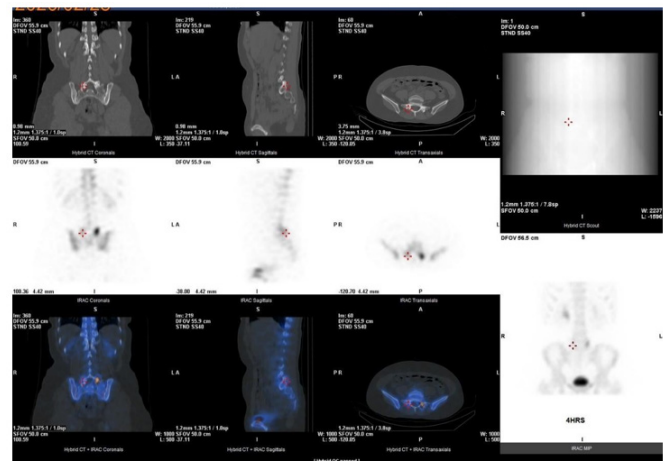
Whole-body Bone SPECT/CT Fusion Imaging. The CT images showed that structural changes characteristic of osteoarthritis, such as sclerosis, are visible in the posterior articular process region of the right L5-S1 area. The fusion images presented that the lesion was in L4/5.
